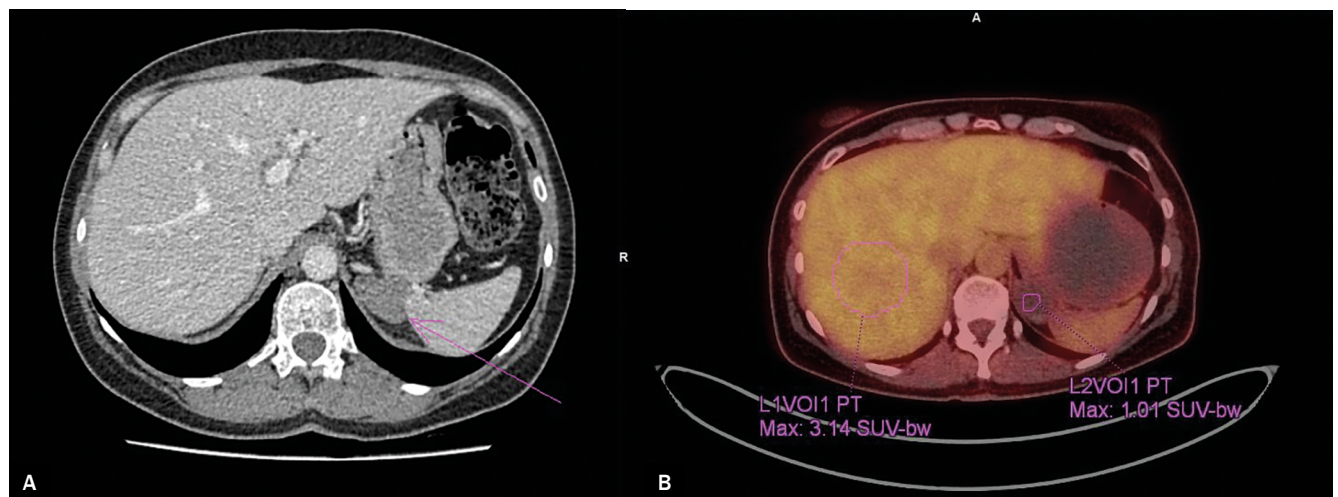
Axial CT (with contrast enhancement) and fused [^{18}F]FDG PET/CT images. Soft tissue lesion located between the stomach, spleen and the left crus of the diaphragm (arrow) which was suspected of recurrence on a CT scan (A). The [^{18}F]FDG PET/CT was performed due to an abnormal CT result. [^{18}F]FDG PET/CT showed no metabolic activity within the lesion (B)
